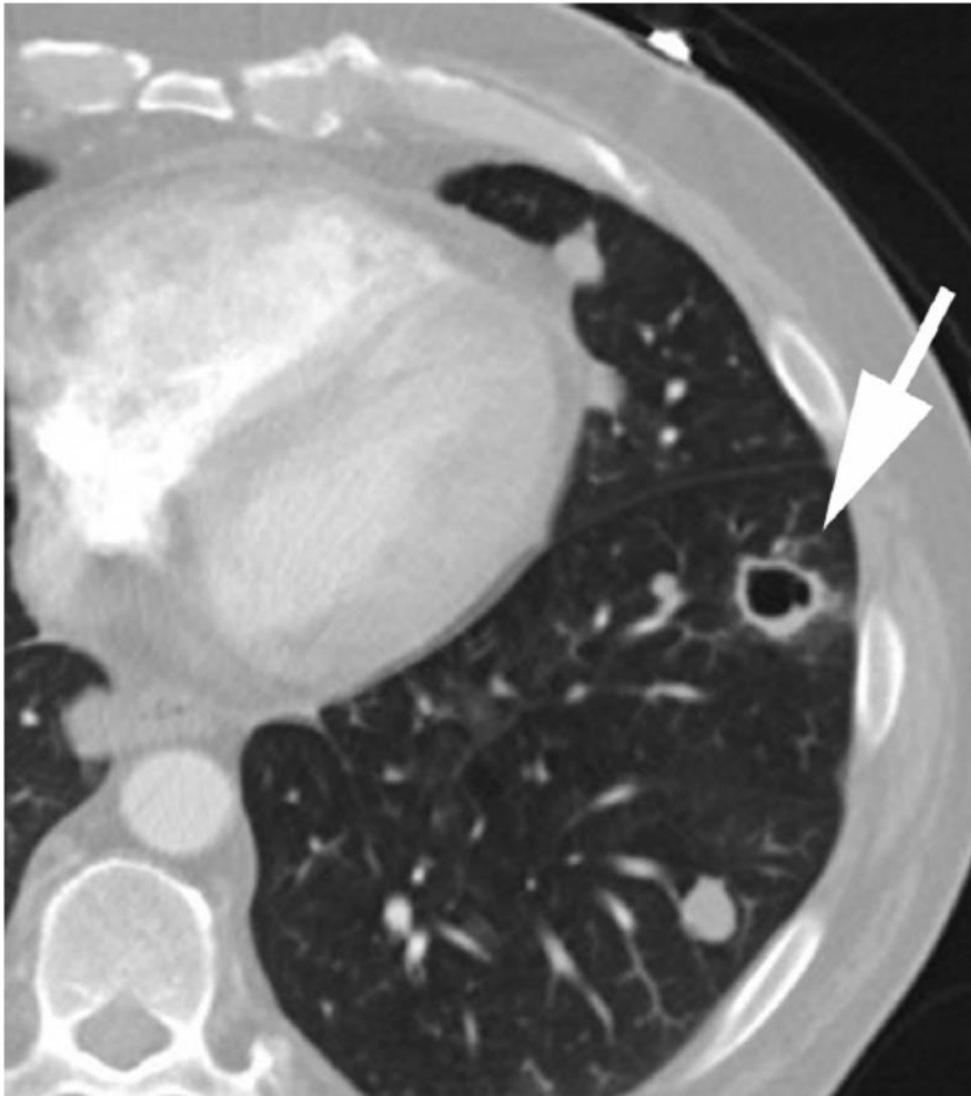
Cavitory metastasis. Axial CT image in 67-year-old man with metastatic squamous cell carcinoma. Note the thicker and more irregular wall of the cavitory metastasis compared with cystic lung disease (arrow).
